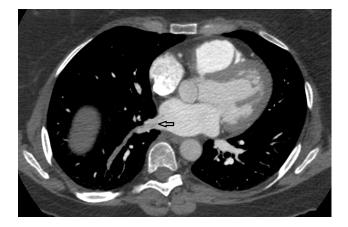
CT pulmonary angiogram showing thrombosis of a right lower lobe segmental pulmonary vein
